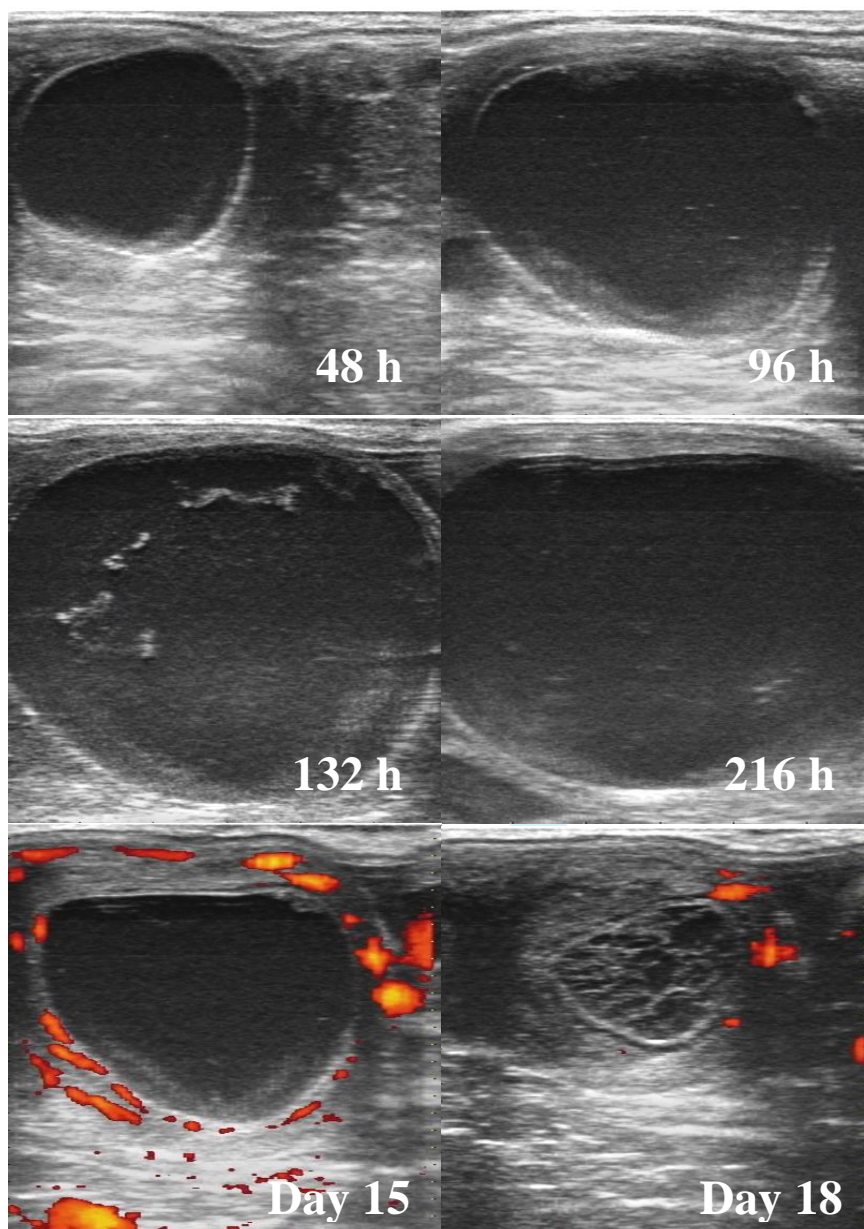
B-Mode and colour-Doppler (Day 15 and Day 18) sonograms of a mare from LUF CLO 33. The mare was treated with 1.7 mg/kg flunixin-meglumine i.v. every 12 h from 0 to 36 h after hCG (0 h) and 250 μ g cloprostenol i.v. at 33, 35 and 36 h after hCG. Note the low score of follicular contents (< 2) resultant from low number of echogenic particles floating within the antrum throughout the LUF lifespan (48 h to 15 days). At one point (132 h) the scant follicular haemorrhage formed small clots of blood decanted at the bottom of the LUF which floated freely upon ballottement of the ovary. The active production of progesterone by the luteinized follicular wall is indicated by the presence of high-intensity colour-Doppler signals around most of the LUF wall circumference (Day 15). The LUF remnant (Day 18) has lost most of its Doppler signals since at this point the luteal tissue had regressed (the mare showed endometrial oedema 18 days post-hCG treatment).
